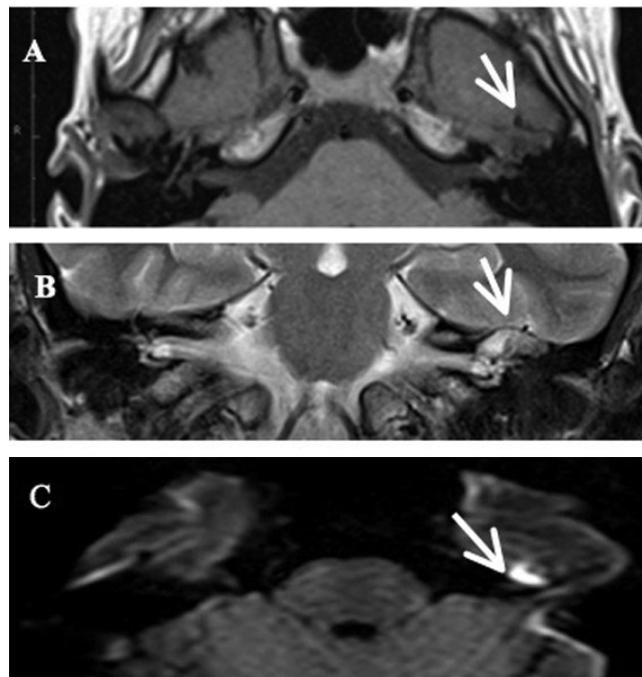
MRI. A. T1-weighted images. B. T2-weighted images. C. DWI. The soft tissue mass was hypointense on T1- and hyperintense on T2-weighted images and extended along the pyramid of the temporal bone. Diffusion-weighted imaging revealed a hyperintense lesion in that area.
